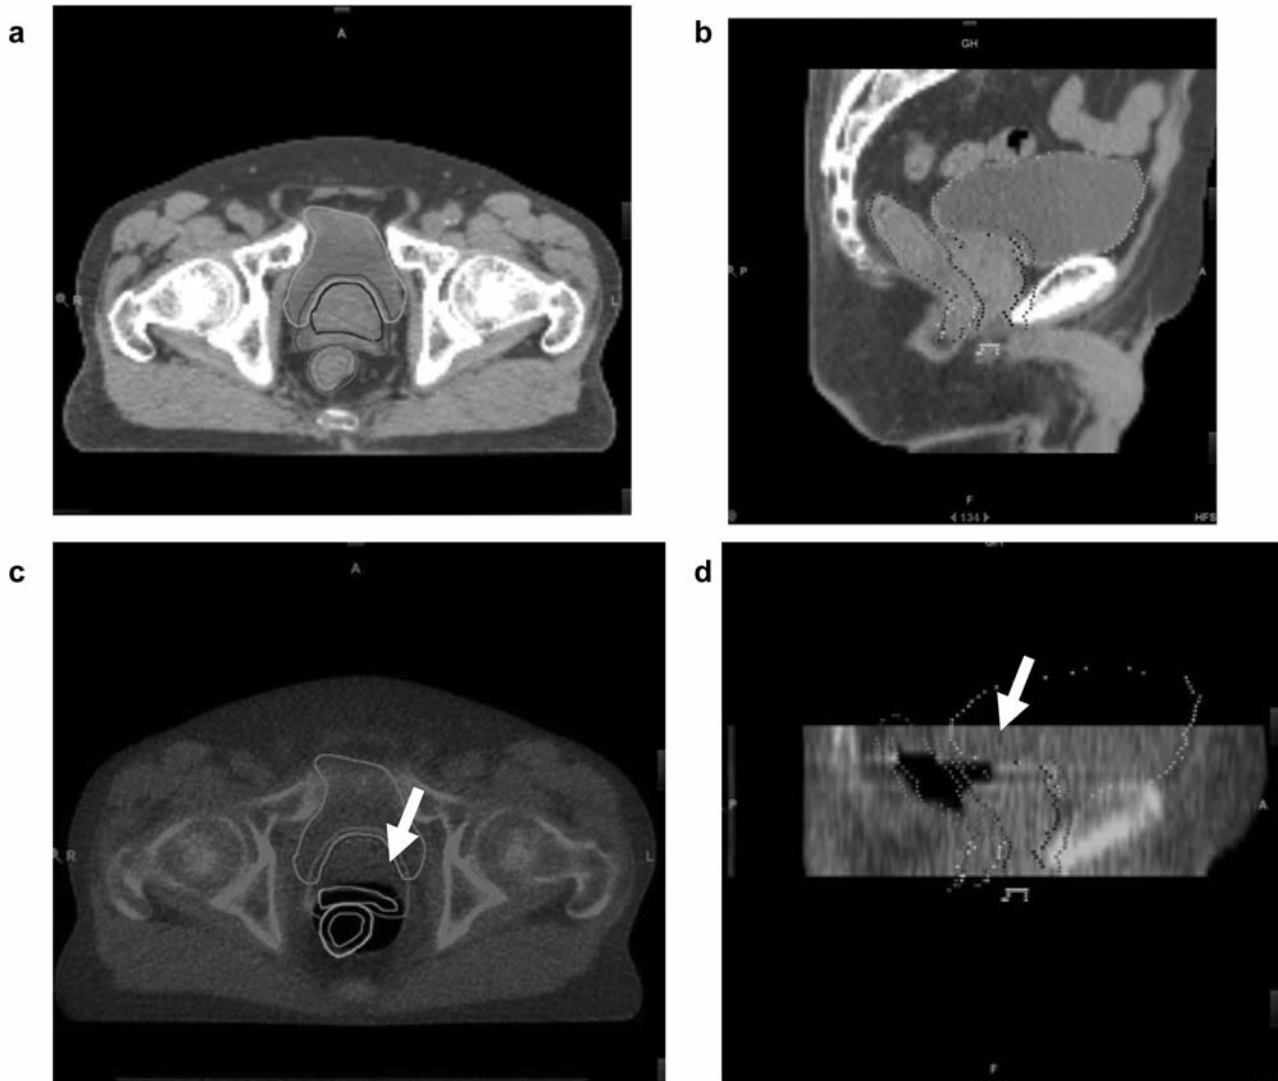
Scheme of action level of rectal dislocation (ARD) required rectal voiding. a) Axial planning CT images (kVCT) and contour of organ at risks, b) sagittal planning CT images (kVCT) and contour of organ at risks, c) axial MVCT image. At the first MVCT scan, this patient's rectum, showed large volumes of gas. Note displacement of rectal contour ≥ 5 mm compared to previous planning CT images. Arrow indicates rectal gas expansion into PTV, d) Sagittal MVCT image. Arrows indicate rectal gas expansion.
